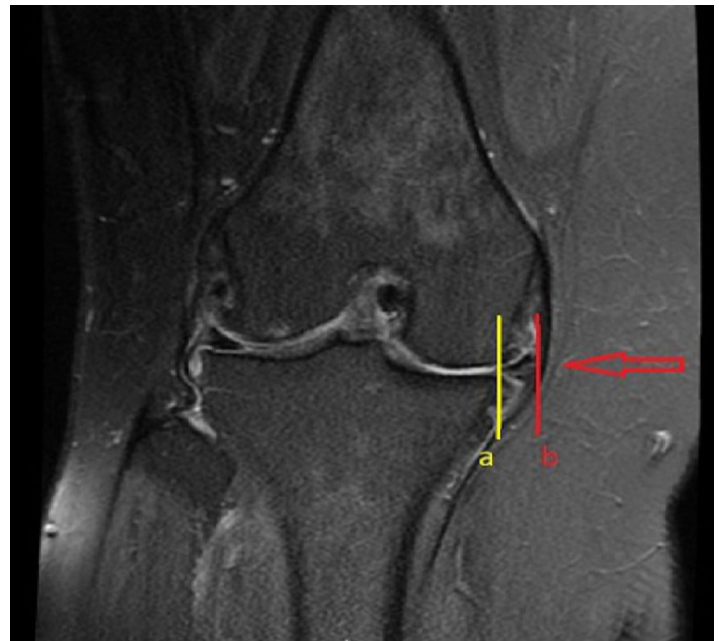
Measurement of medial meniscal extrusion. Extrusion is determined by measuring the distance in mm between the two perpendicular lines in the image showing the femoral medial condyle. First, a proper slice is selected in the coronal plane magnetic resonance imaging. Second, the exclusion of osteophytes are performed. Third, a perpendicular line (a) is drawn at a point at which the medial tibial plateau transitions from horizontal to vertical, then another perpendicular line (b) is drawn intersecting the outermost edge of the medial meniscus. The distance between the lines (a) and (b) is measured.
